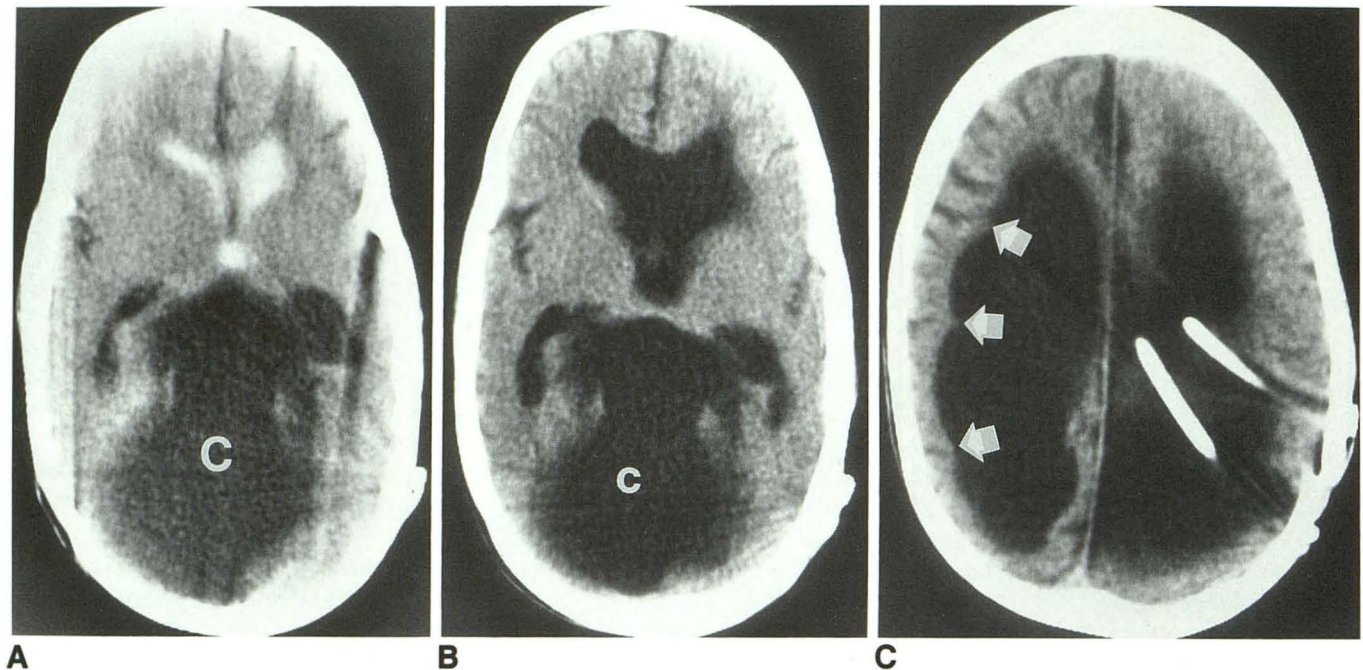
Dandy-Walker cyst with postinflammatory compartmentalization of the lateral ventricles (case 2). The CT ventriculogram shows a CSF-containing space (c) completely occupying the posterior fossa and protruding through the hiatus into the supratentorial space (A). Only the frontal horns and the third ventricle are opacified; the remaining ventricular spaces do not communicate with the frontal horns. After surgery and lysis of adhesions the lateral ventricles are no longer compressed and have expanded (B and C). Note that the diminution of volume and pressure results on one hand in some retraction of the wall of the lateral ventricle with visualization of the cortical sulci (arrows); on the other hand the frontal horns have enlarged beyond their expected size (C).
